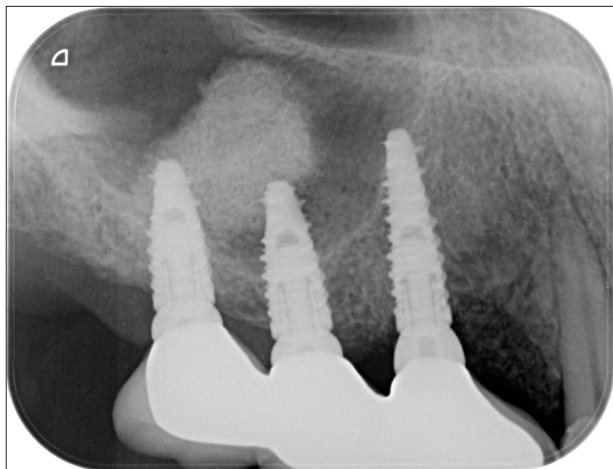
The radiographic outcome immediately after the surgery
